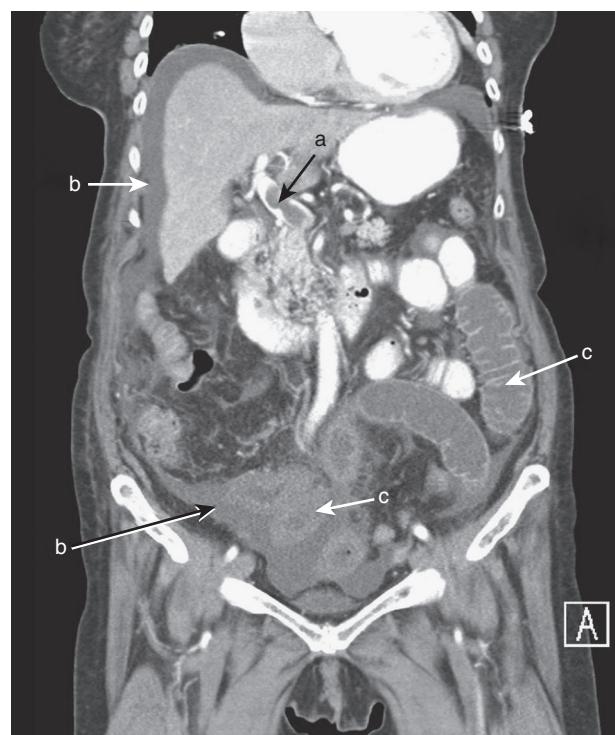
Multidetector computed tomography with multiplanar reconstruction in the coronal view shows thrombosis in the extrahepatic portion of the portal vein (*a*), ascites (*b*), and dilated and edematous small bowel loops (*c*).
